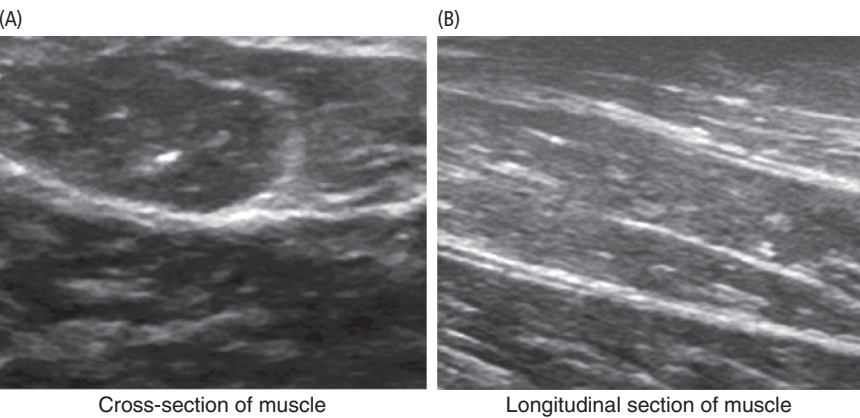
Ultrasound appearance of muscle
